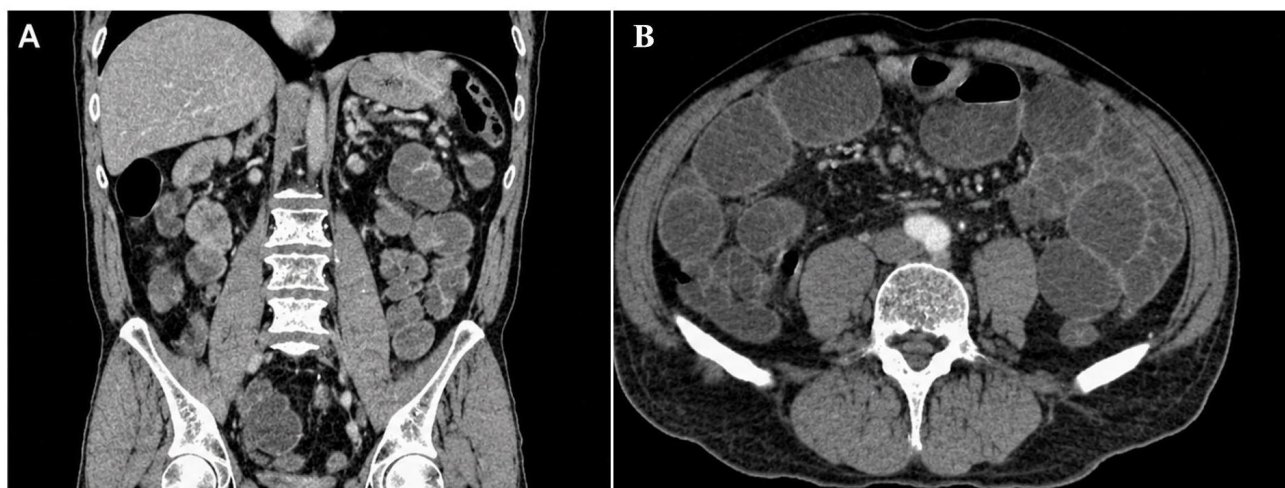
Abdominal computed tomography (CT) findings demonstrating acute mechanical intestinal obstruction caused by a mesenteric mass. (A) Coronal contrast-enhanced abdominal CT image demonstrating marked dilatation of small bowel loops with multiple air–fluid levels. A well-defined soft tissue density mass is observed adjacent to the terminal ileum, causing near-complete luminal obstruction. (B) Axial CT image showing dilated small bowel loops consistent with mechanical intestinal obstruction. A mesenteric mass lesion compressing the intestinal lumen is also visualized.
